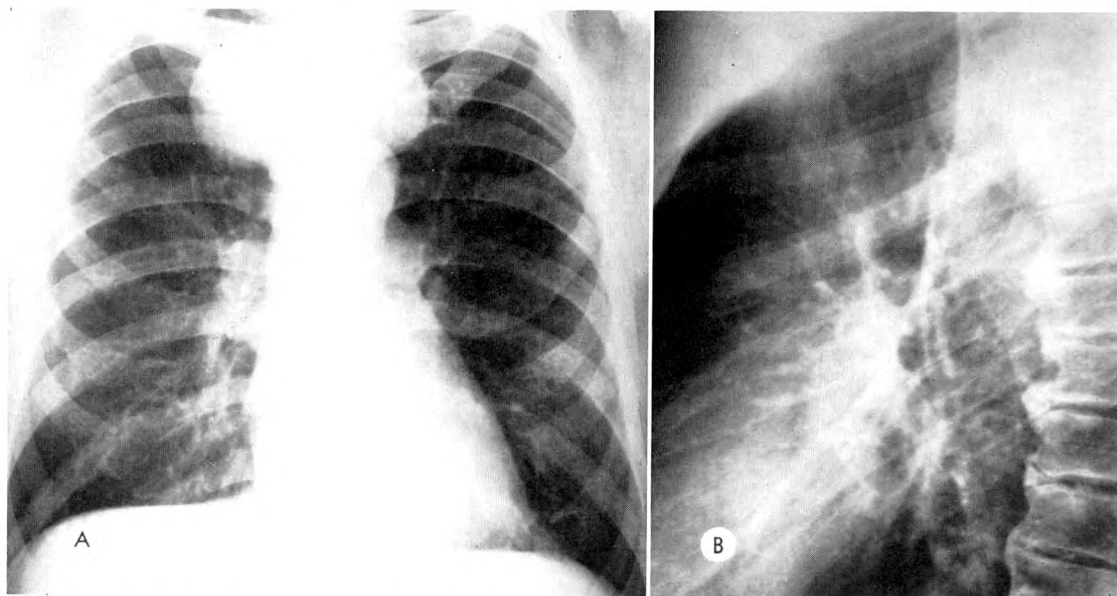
(A) Frontal teleroentgenogram of the chest showing the rounded superior mediastinal tumor. (B) Lateral roentgenogram of the chest showing the posterior superior mediastinal location of the tumor.
